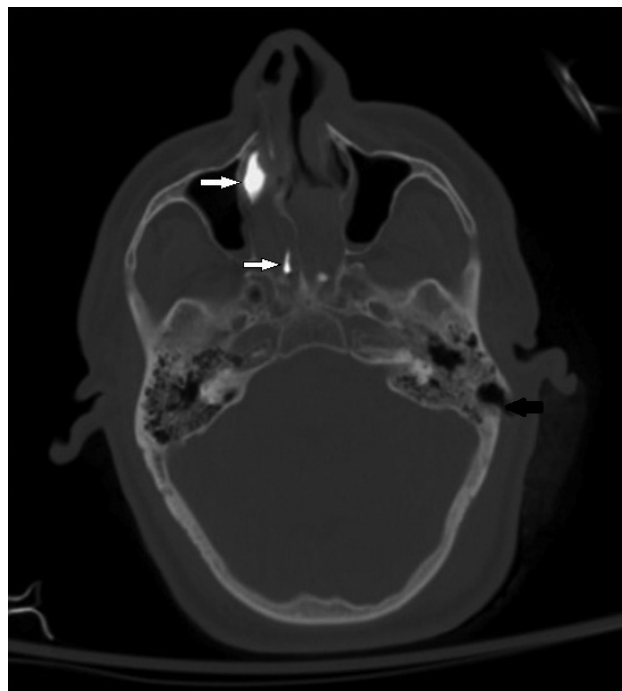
Axial computed tomography scan showing bullet entry wound and trajectory (*black arrow*) through the left mastoid and metallic fragments within the nasal cavity (*white arrows*).
